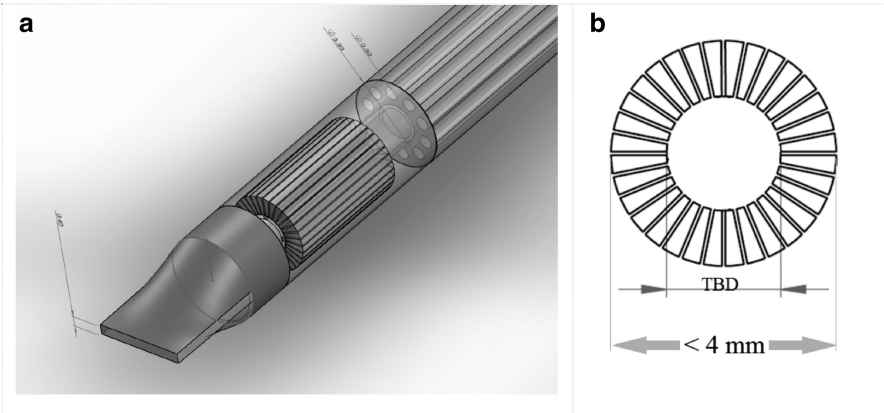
The primary objective of this thesis is to fabricate the proposed device, in order to examine its suitability for providing real-time navigation in pedicle screw insertion. (a) Perspective view of the ultrasound transducer array probe incorporated into the surgical toolkit. (b) Cross section view of the array
